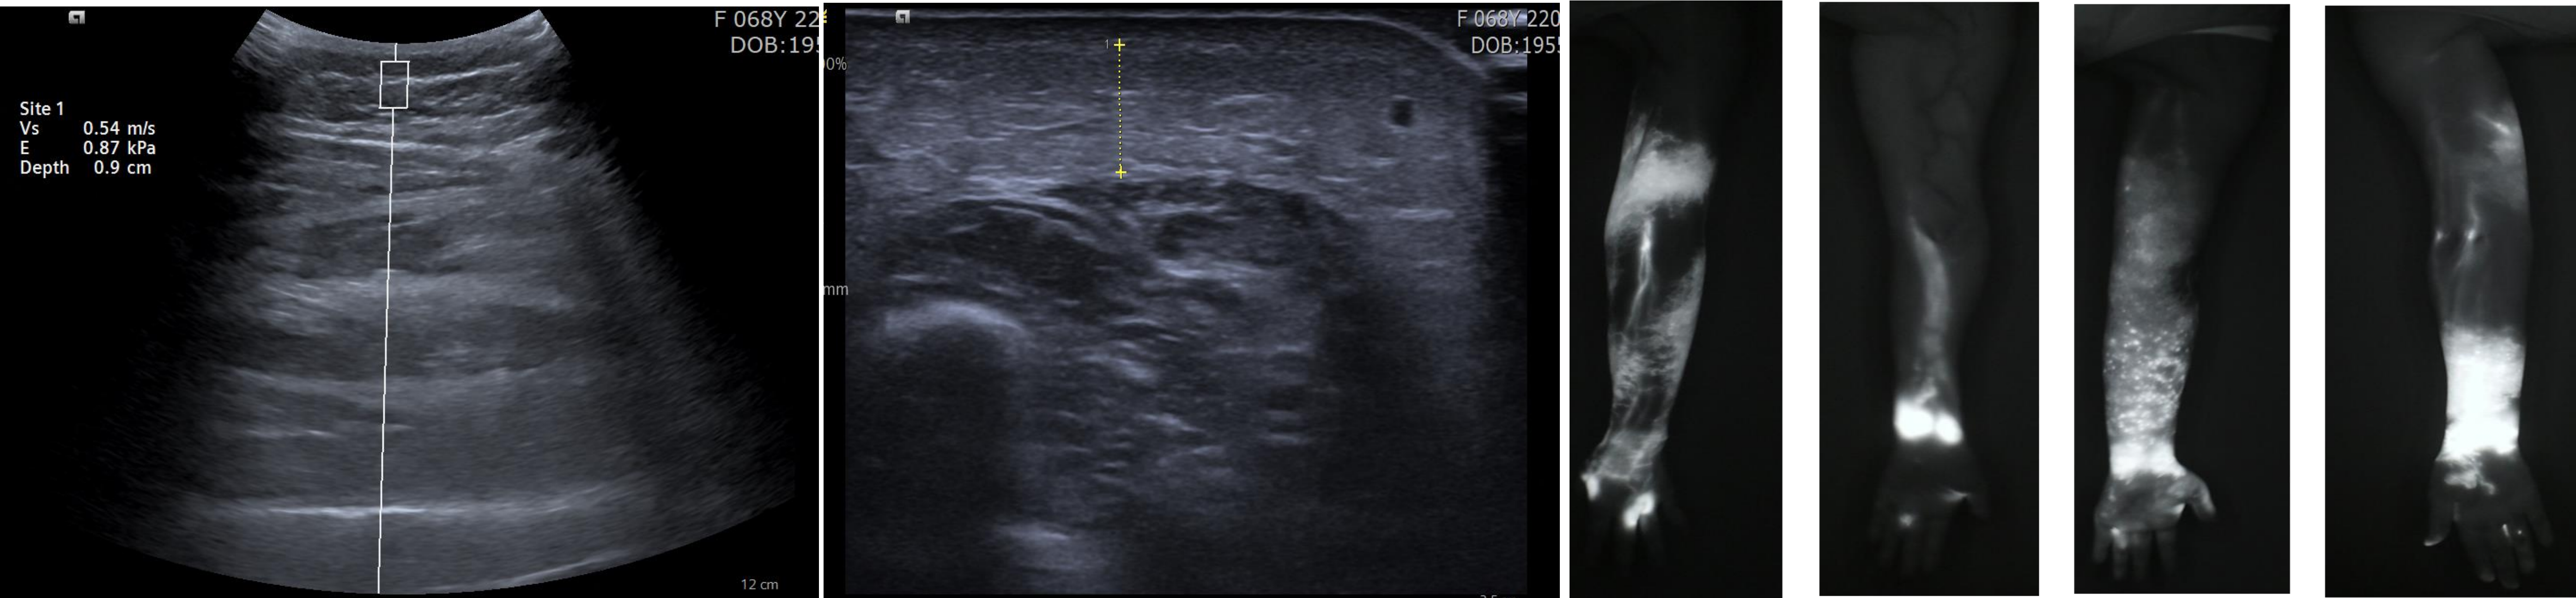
Shear wave velocity and subcutaneous thickness measurement using ultrasonography
